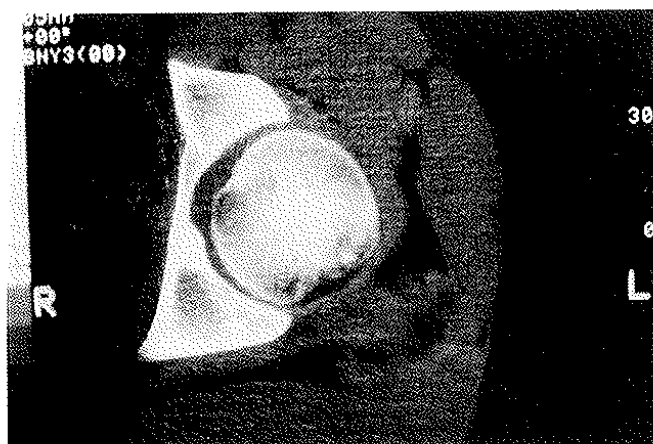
CT of left hip shows area of sclerosis in the inner acetabulum.
